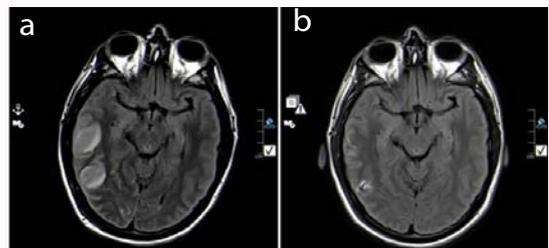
(a) Initial axial FLAIR demonstrates the edema in the right temporal and parietal lobes. (b) Follow up 5 months later demonstrates encephalomalacia in the area that previously demonstrated restricted diffusion (see Figure 10) and normalization of the area that showed vasogenic edema.
